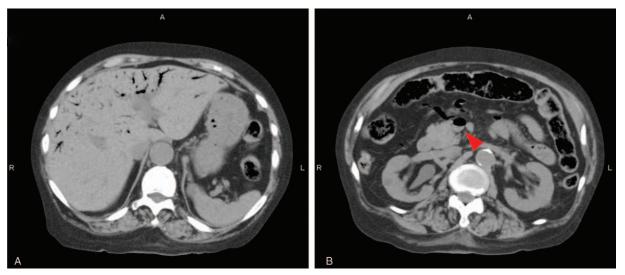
A, B, Representative noncontrast abdominal CT images. A, Massive HPVG was observed. B, Massive intravascular gas was observed. The red arrowhead indicates gas in the superior mesenteric vein. CT=computed tomography, HPVG=hepatic portal vein gas.
